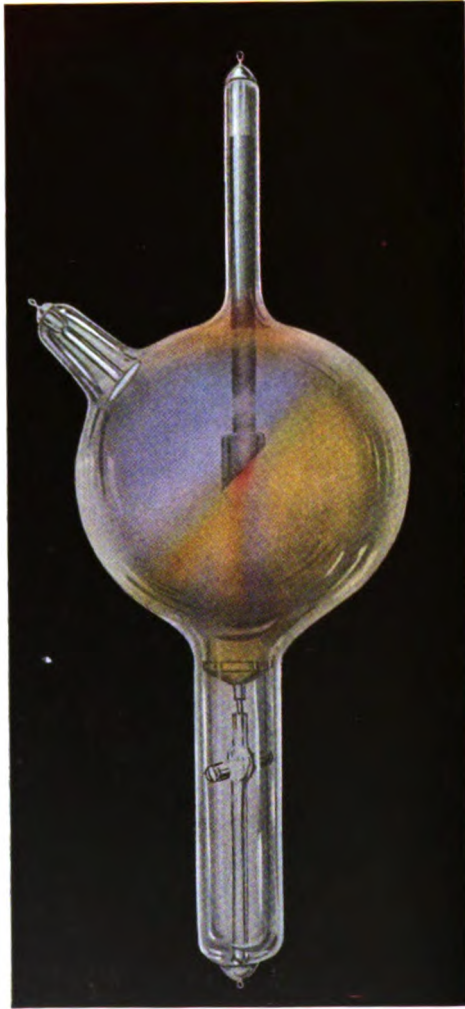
X-ray tube in operation. Exclusively inverse. Connected with the wrong poles of the x-ray coil.
